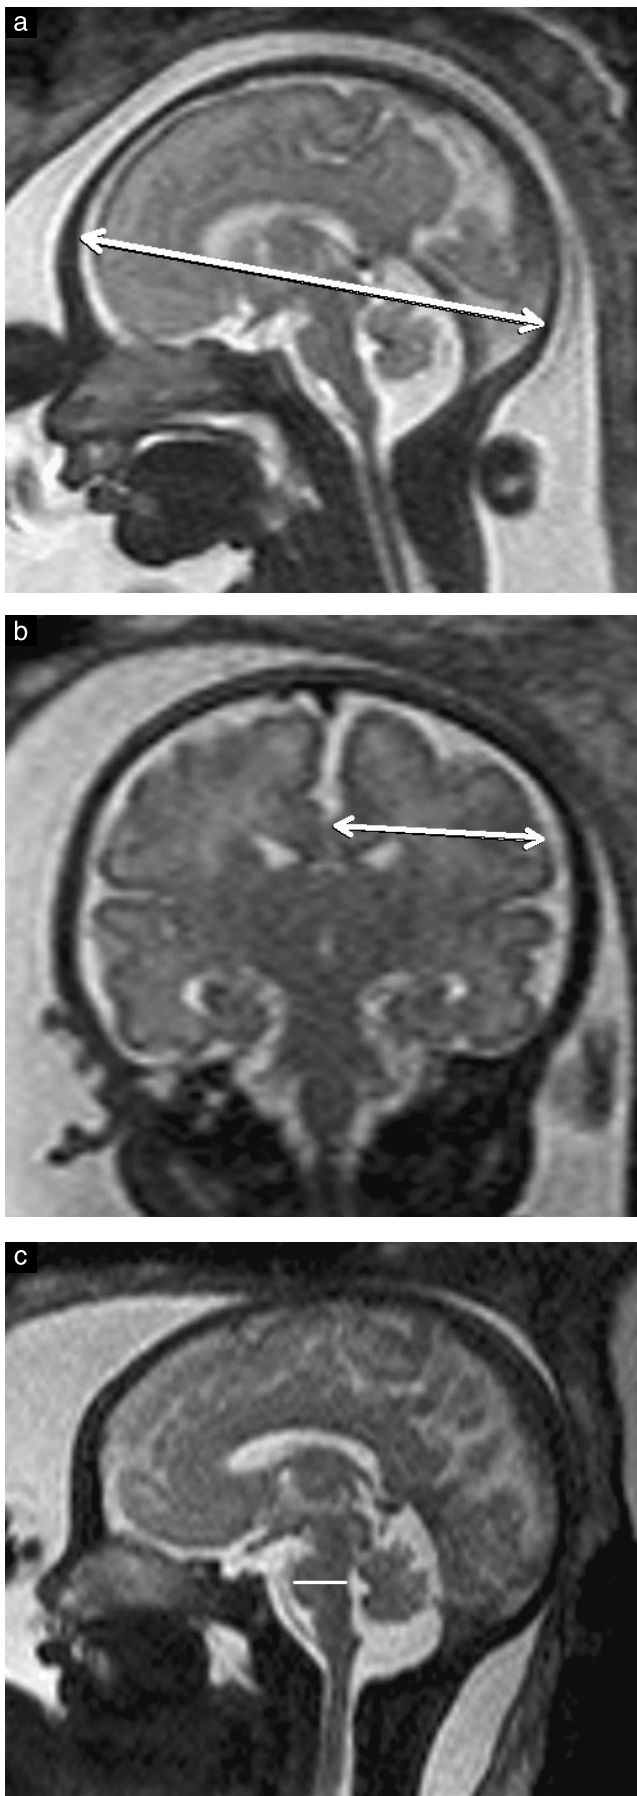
Midline sagittal T2-weighted magnetic resonance imaging slice, showing measurement of: bone fronto-occipital diameter (a); left cerebral biparietal diameter (b); and anteroposterior diameter of the pons (c).
